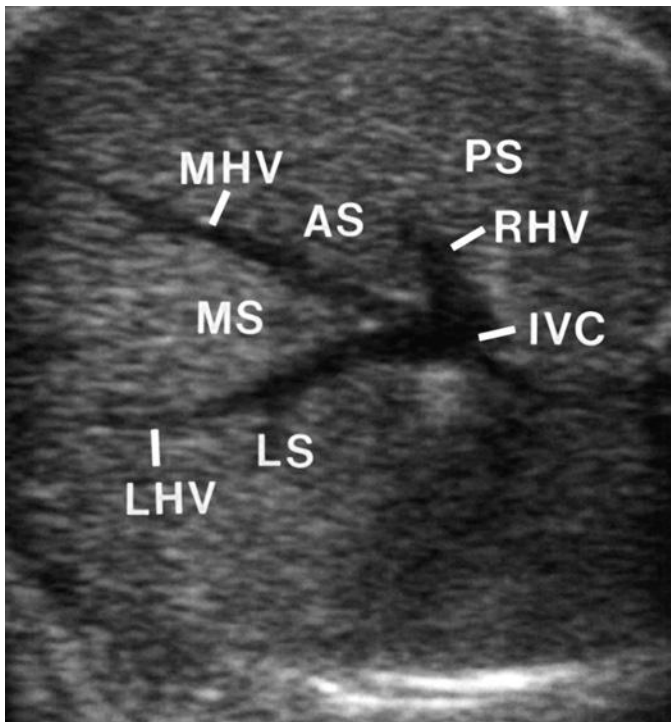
Sonogram through the long axis of the proximal fetal hepatic veins: IVC, inferior vena cava; LHV, left hepatic vein; MHV, middle hepatic vein; RHV, right hepatic vein. These veins divide the liver into lobes and segments: AS and PS, anterior and posterior segments of the right hepatic lobe; MS and LS, medial and lateral segments of the left hepatic lobe.
